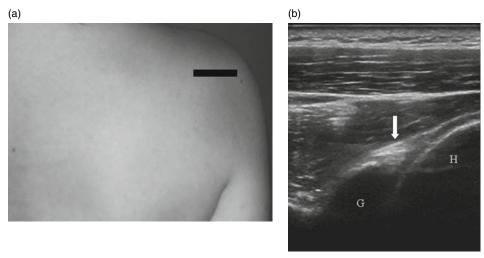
Posterior labrum: (a) transducer position for evaluation of the posterior labrum and (b) corresponding ultrasound image demonstrating the hyperechoic triangular labrum (arrow) between the humeral head (H) and glenoid (G).
